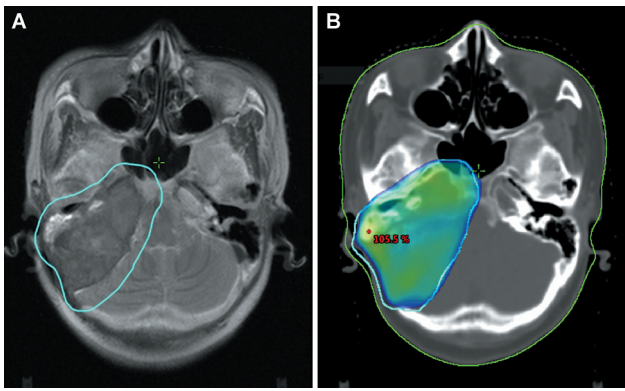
CT and MRI fusion image shows adequate coverage of residual tumor and postoperative bed (A) and dose distribution showing 95% coverage of the planning target volume (cyan) (B) at the right temporal bone.
